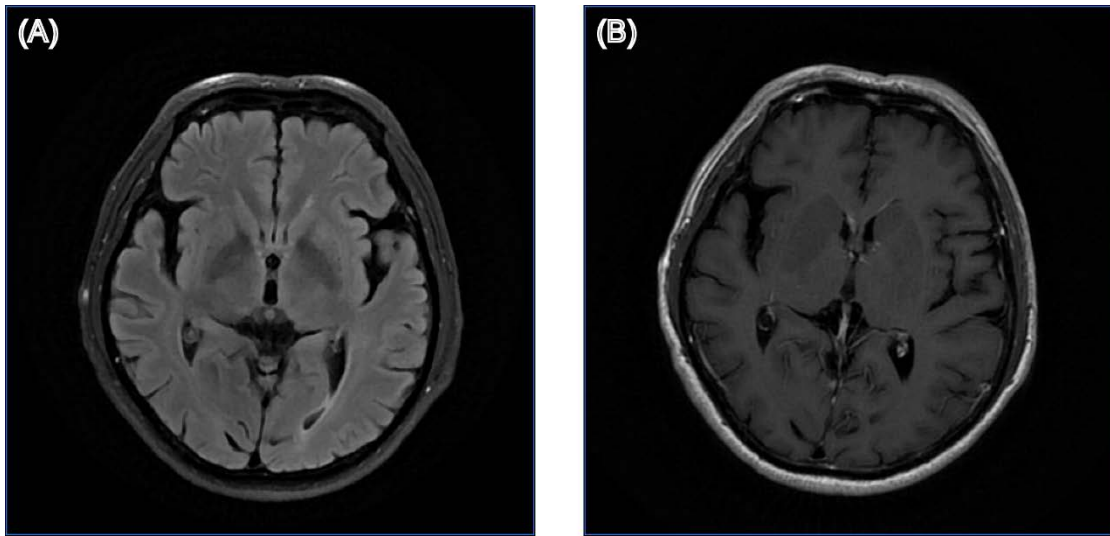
Structural brain MRI images of patient 13. (A) T2-weighted fluid-attenuated inversion recovery (T2-FLAIR) image; (B) Gadolinium-enhanced T1-weighted (Gd-T1w) image.
